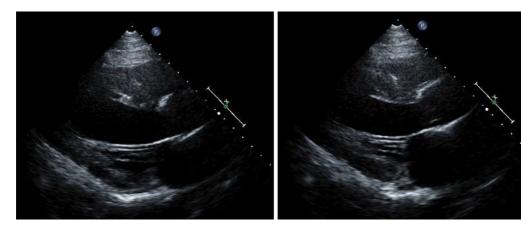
Cardiac ultrasonography findings. Left ventricular contraction is moderately deteriorated with diffuse hypokinesis, although the regional left ventricular wall motion is normal. The left atrium and left ventricle are dilated. No valvular dysfunction is found. Aortic diameter: 23 mm, left atrial dimension: 44 mm, interventricular septum thickness: 13 mm, posterior wall thickness: 14 mm, left ventricular end-diastolic diameter: 54 mm, left ventricular end-systolic diameter: 45 mm, end-diastolic volume: 141 mL, end-systolic volume: 92 mL, systolic volume: 49 mL, ejection fraction: 35%, fractional shortening: 17%, E wave 770 mm/s, A wave 879 mm/s, E/A 0.9, E/e' med 15.3, E/e' lat 14.9.
